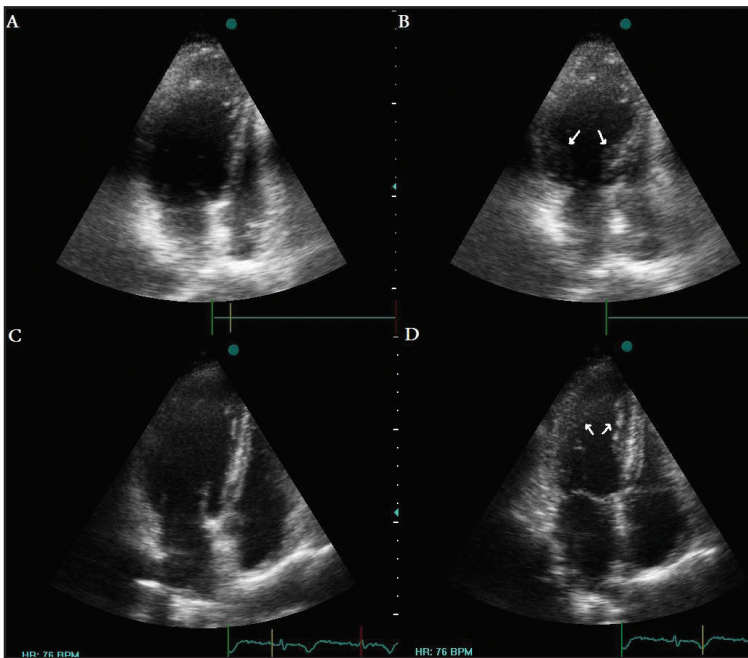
Diastolic (A) and systolic (B) frames of apical 4-chamber view of transthoracic echocardiography in intensive care unit showing akinetic mid and apical segments and hyperkinetic basal segments (arrows). After serial visits, apical 4-chamber view of control transthoracic echocardiography showing normal left ventricular wall motions during diastole (C) and systole (D). Arrows indicate normal thickening of previously abnormal segments
